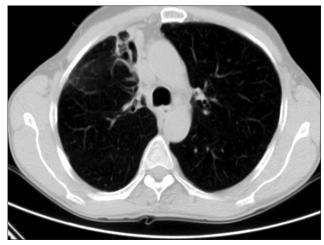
CT scan shows the resolved lesion
